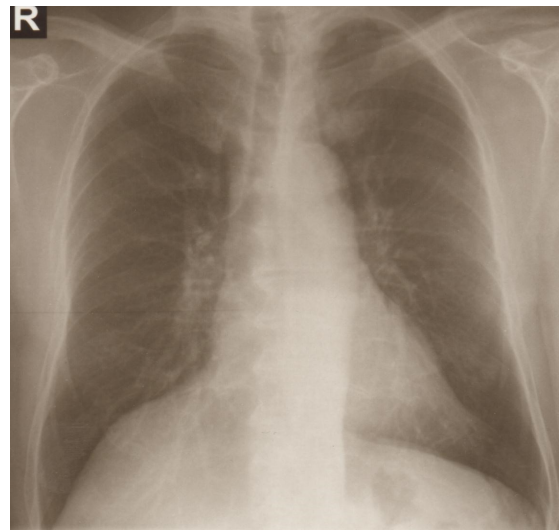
Chest X-ray. COPD. Male age 74
